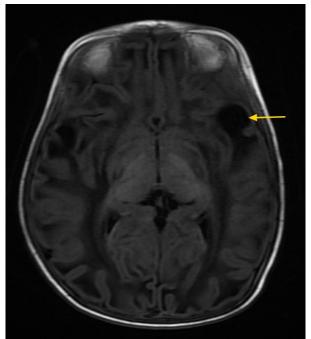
Axial T1 MRI showing a CSF intense cyst in left temporal lobe subcortex (arrow).
